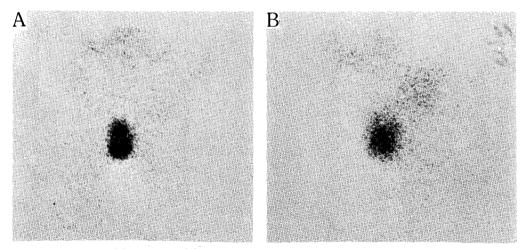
Case IV. Anterior (a) and lateral (b) views of 99mTc scintigraph show a oval increased activity at mildline of upper anterior neck, which corresponds to clinically palpable mass on neck.
